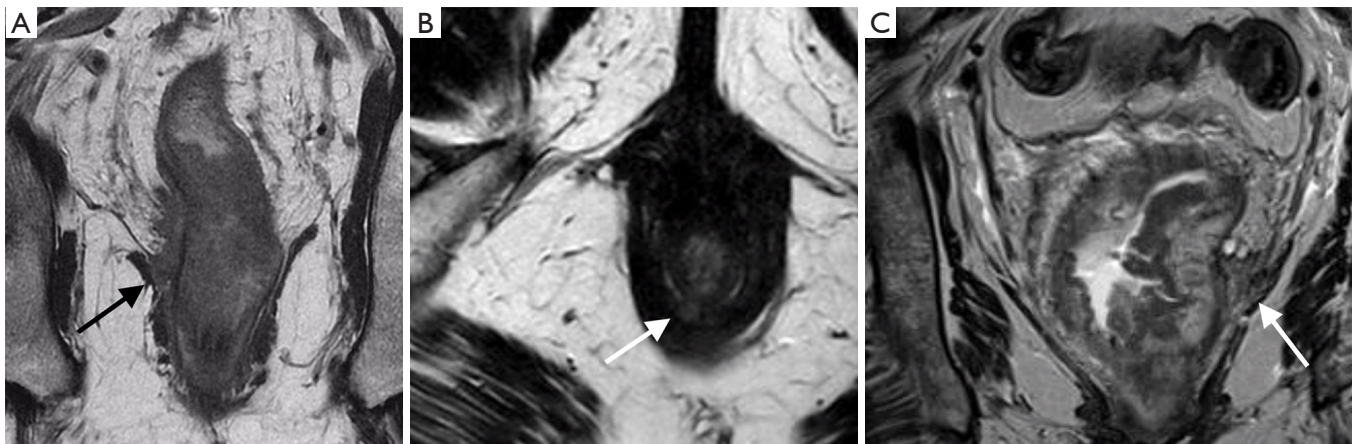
MR images of low rectal cancers in three patients: (A) coronal image shows tumour extension into the intersphincteric space, contacting the right levator ani muscle; (B) axial oblique image shows a tumour invading the puborectalis sling; (C) coronal image shows tumour extending into the intersphincteric space and contacting the left levator ani. Extralevator AP surgery is required.
